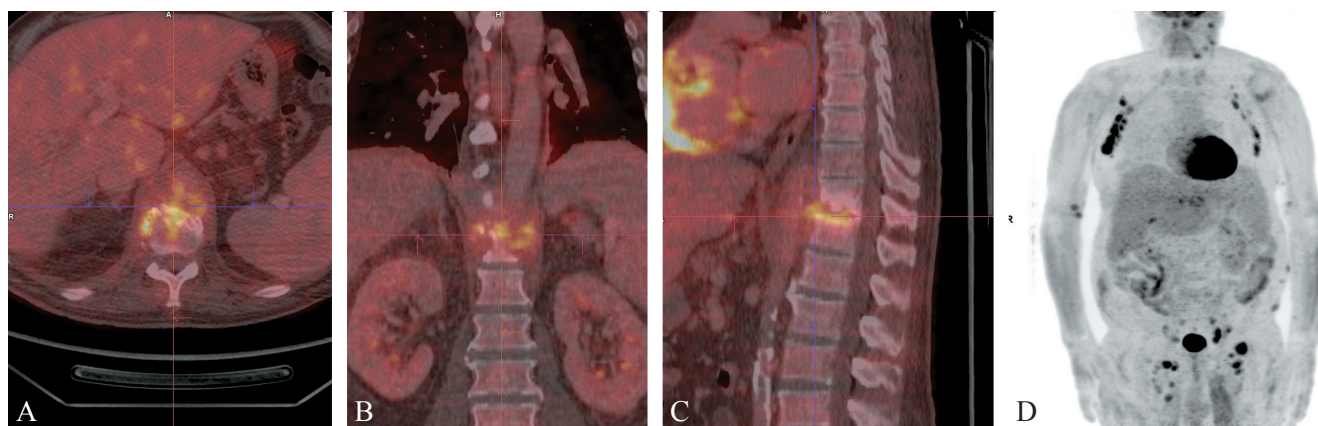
Axial (A), coronal (B) and sagittal (C) fused PET/CT images and MIP image (D) showing spondylodiscitis and abscess between the T11 and T12 vertebrae.
